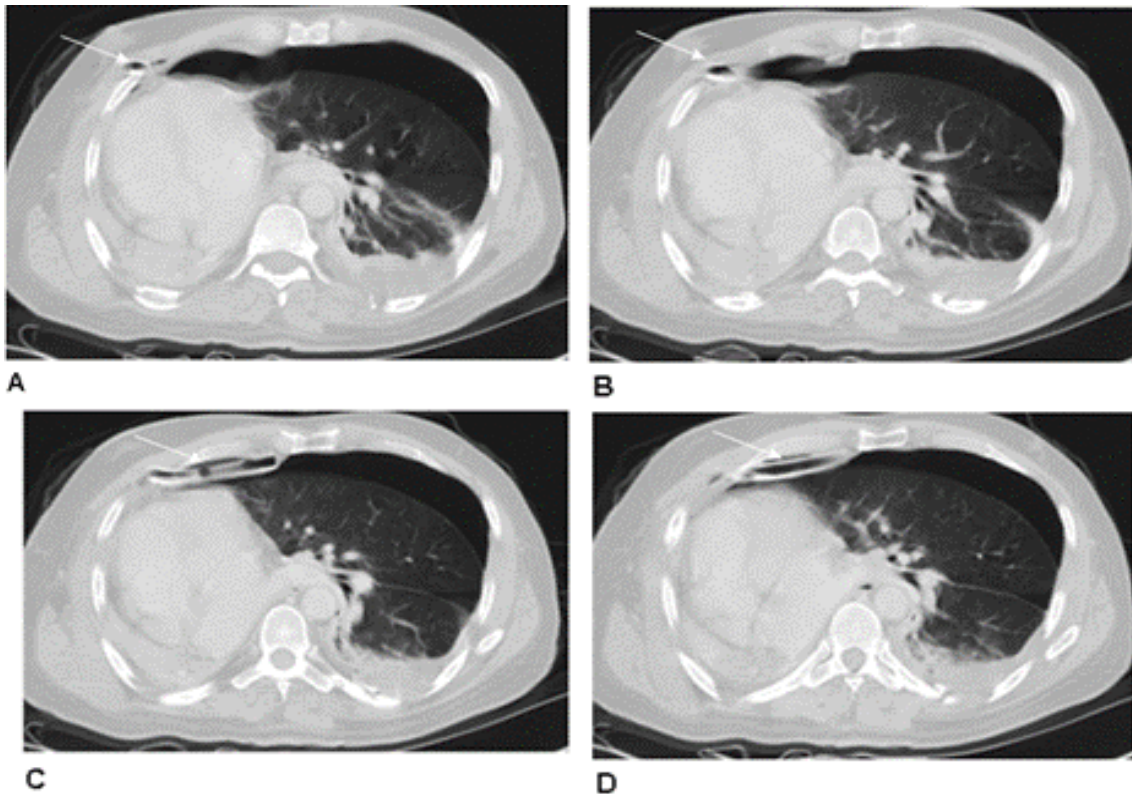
(Case 15): 48 years old male presented with right side chest discomfort and difficulty of breathing. The chest tube was inserted with a clinical diagnosis of right pleural effusion. Chest CT showed a completely collapsed right lung with the heart occupying the right hemithorax. Chest tube inserted from the right side crossed anterior to the heart and punctured the hyperinflated left lung causing left pneumothorax.
